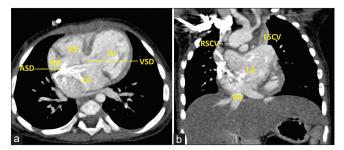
Maximal intensity projection computed tomography angiography images in axial (a) and coronal (b) plane, at the level of left-sided atrium, shows hypoplasia of right-sided atrium and right ventricle with all hepatic veins, right and left superior caval veins connecting anomalously to the left-sided atrium. A small atrial septal defect and a large ventricular septal defect is also seen. The patient also had severe right ventricular outflow tract obstruction (not shown here)
